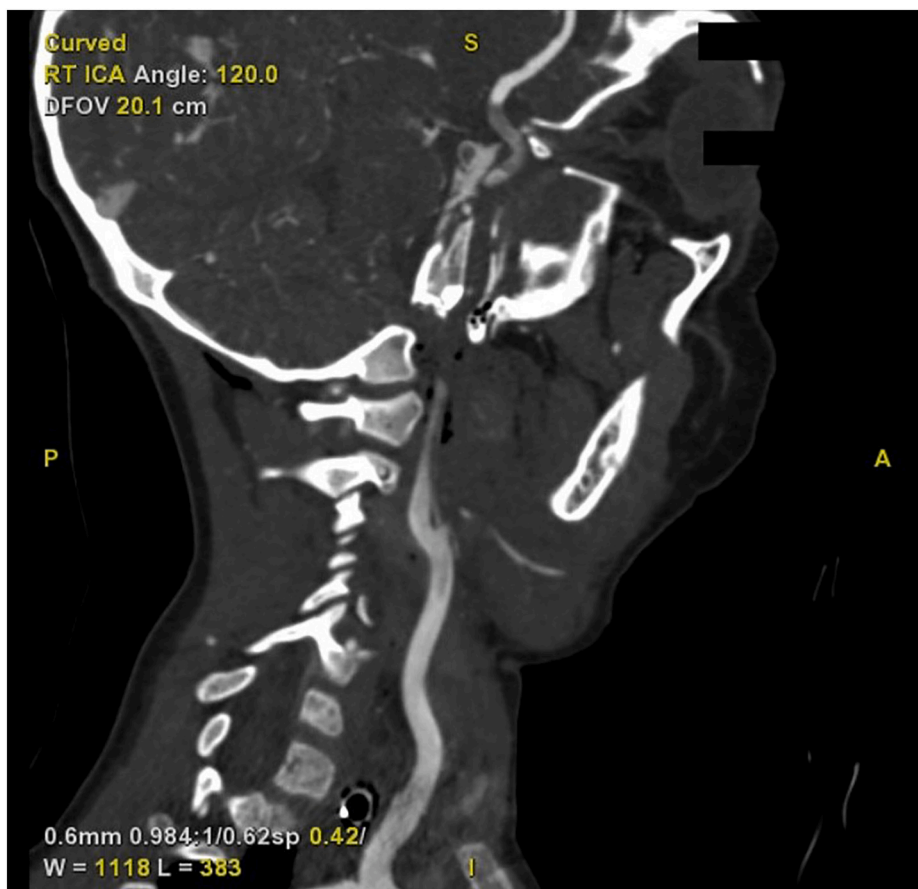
Sagittal CT angiogram demonstrating a perfusion deficit of the right internal carotid artery.
